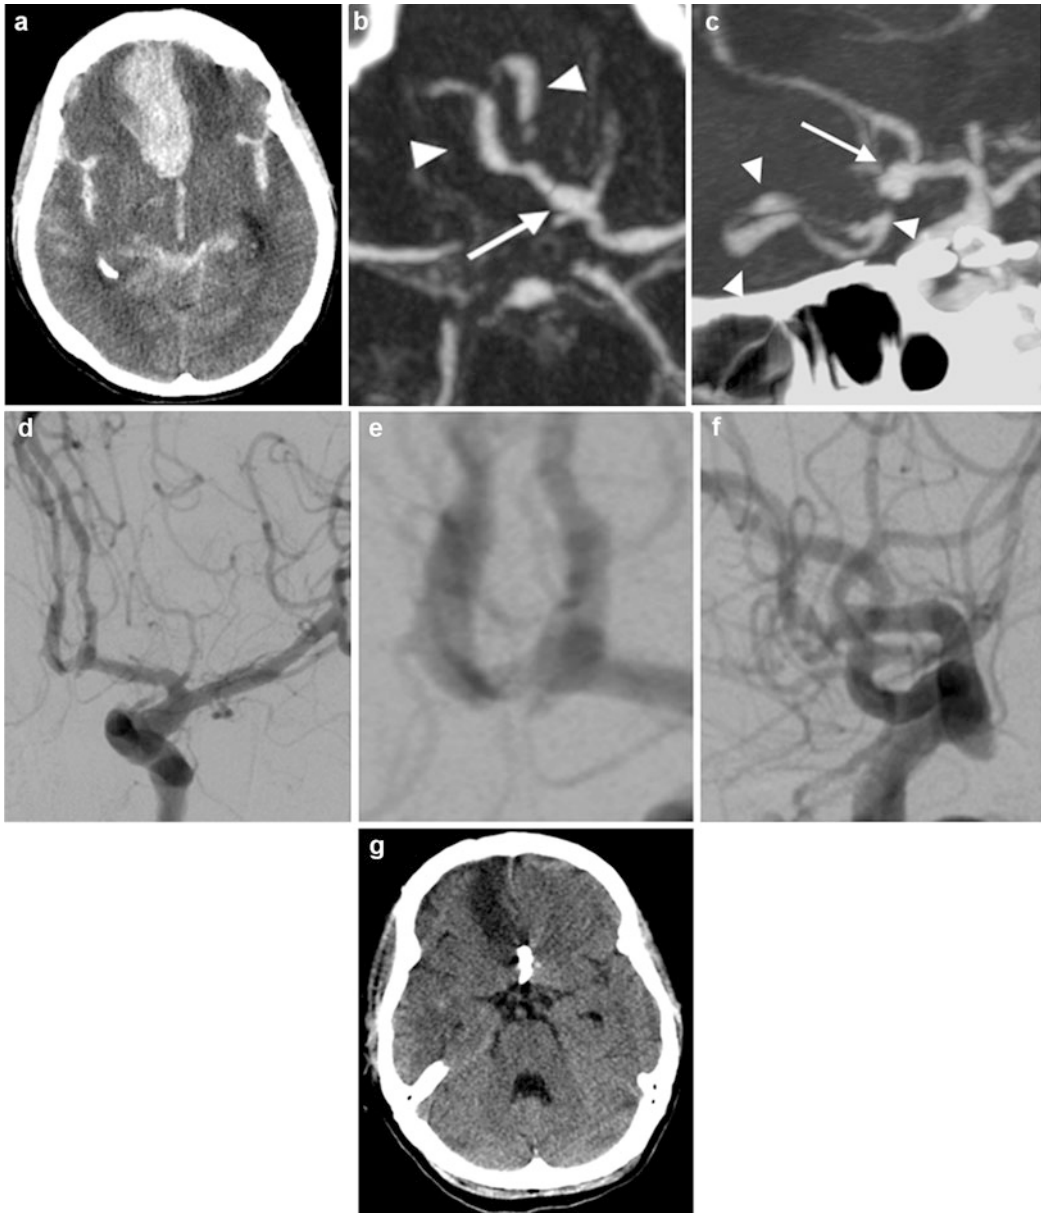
A 52-year-old female patient with a spontaneous SAH, graded as Hunt and Hess III and Fisher 4. She was admitted to hospital after a sudden onset of headache, nausea, and her first generalized epileptic seizure. Clinical deterioration occurred immediately after arrival at the emergency room with a loss of consciousness during the CT/CTA examination, requiring subsequent intubation. The initial emergency NCCT showed an extensive SAH with an intracerebral hemorrhage (ICH) in the right frontal lobe (a). CTA revealed an aneurysm of the anterior communicating artery (AcomA, arrow) with extravasation of contrast medium (arrowhead) (b, c). The goals of the treatment were to prevent further hemorrhage, to occlude
